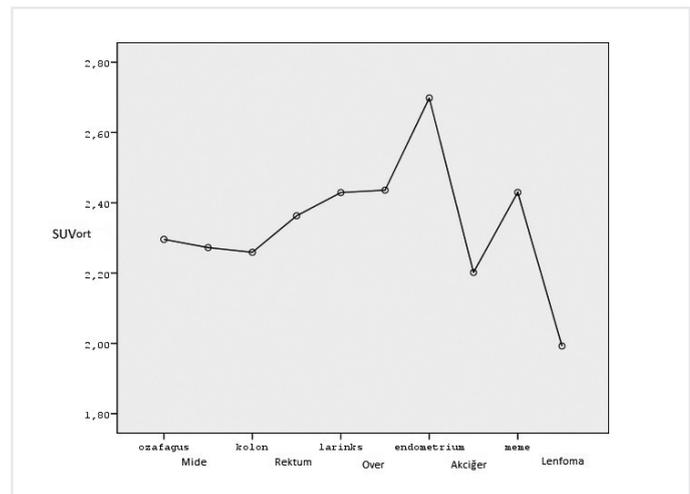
Mean SUV_{mean} measurements of ROIs plotted on the right lobe of liver according to diagnosis
